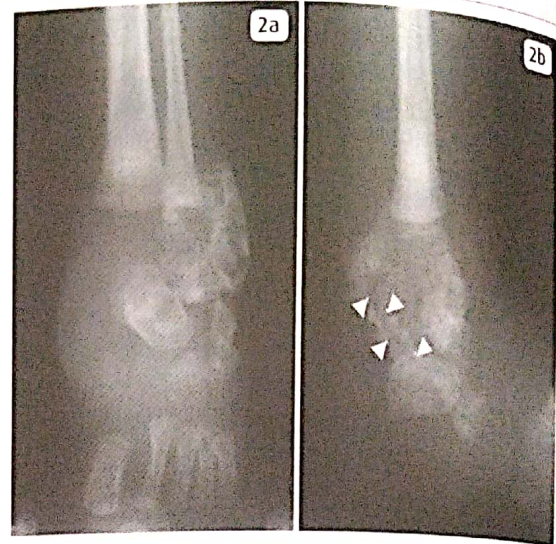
Left ankle X-rays
